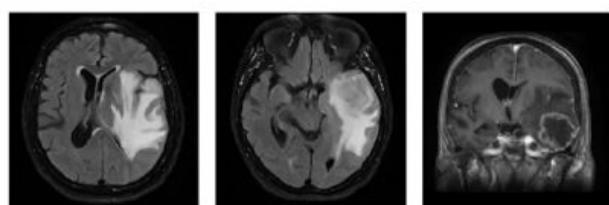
Brain MRI with contrast.
